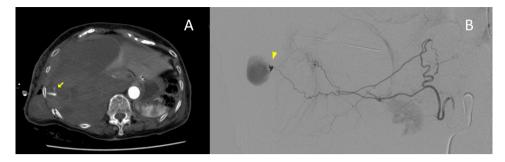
Computed tomography and angiography in Case 2. (A) Repeat computed tomography revealed a right tension hemothorax and recurrent contrast extravasation. (B) New contrast extravasation from the right inferior phrenic artery was identified
